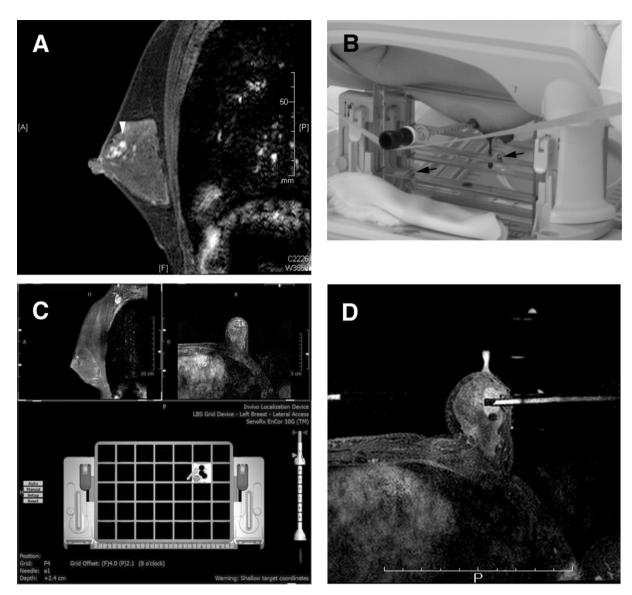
A case of a breast lesion examined by MRI-guided VAB twice. (A, B) In the first examination a biopsy needle was inserted manually. The procedural duration was 75 min. (A) An MR image showing the location of the target lesion (arrowhead). (B) A photograph showing an obturator after inserting a biopsy needle into the target, based on the 3-dimensional distance manually calculated from two fiducial markers (arrows). (C, D) In the second examination a biopsy needle was guided using a CAD system. The procedural duration was 60 min. (C) An image indicating the location in the grid and depth of the target lesion automatically calculated on a CAD system. (D) An MR image showing an obturator after inserting a biopsy needle in accordance with the calculation result.
